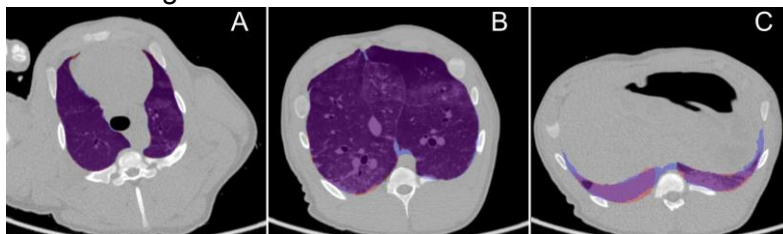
Example of axial slices of CT images with superposition of manual and automatic segmentations. (a) Top, (b) middle and (c) bottom slices of the lung. Manual and automatic segmentations are highlighted in orange and blue, respectively, while their intersection is highlighted in purple.
